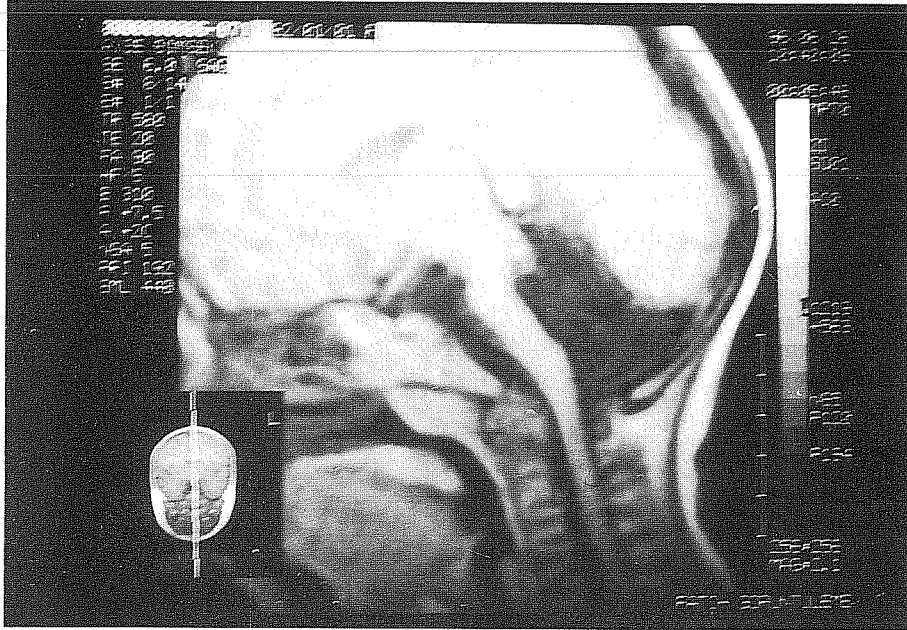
Severe cerebellar hypoplasia has sometimes been termed Chiari IV malformation. Finding in this very rare entity include absent or severely hypoplastic cerebellum, small brain stem and large posterior fossa cerebrospinal fluid spaces. T1 weighted magnetic resonance image shows large ventriculus and absence of the cerebellum.
